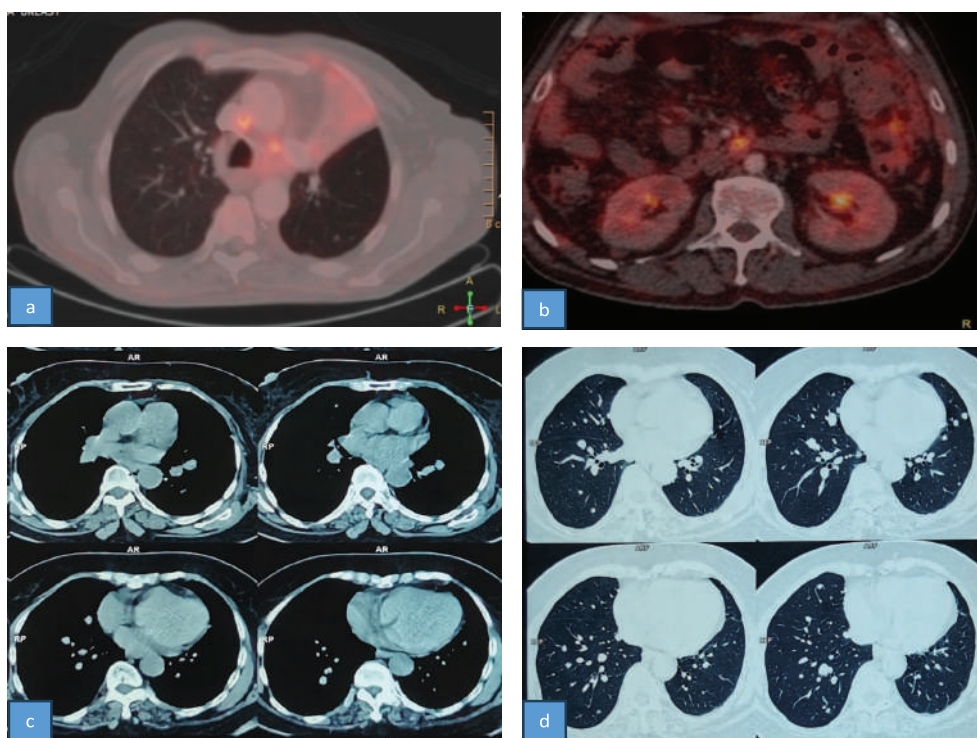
18F FDG PET-CT scan showing intense FDG avid mediastinal (a) and abdominal lymph nodes (b) in a patient of PTC with persistently low Tg level. Chest HRCT showed mediastinal (c) and lung (d) window in a patient of PTC with low Tg level showing multiple nodular metastatic lesions in all lobe of both lungs.
